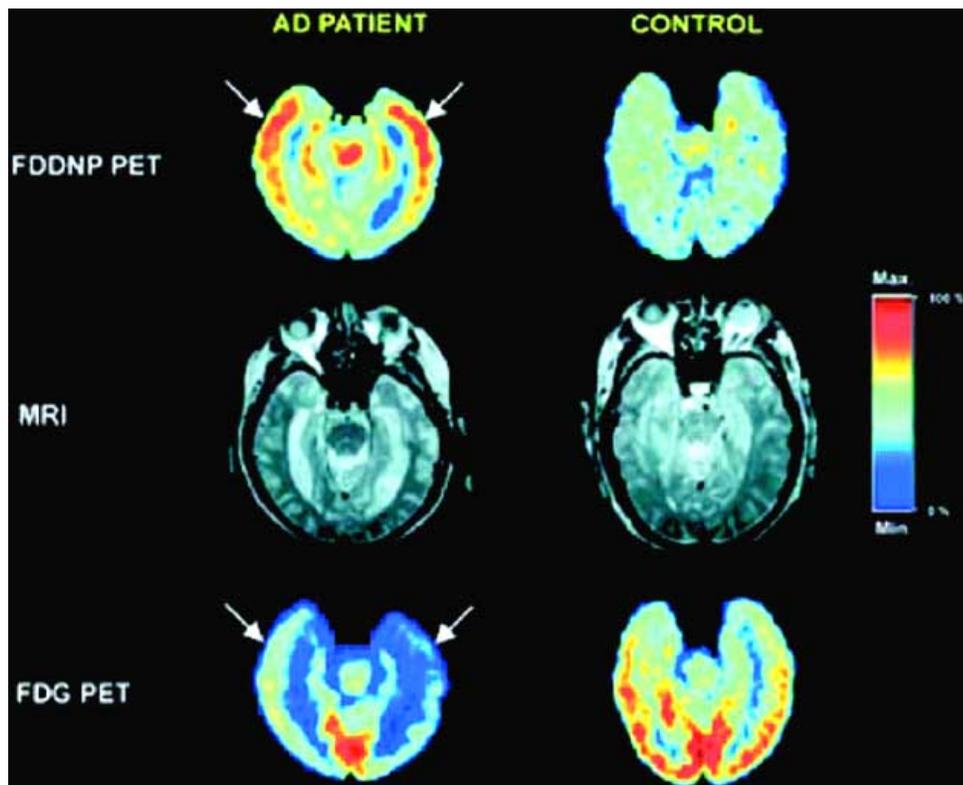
^{18}F -FDDNP-PET, MRI, and FDG-PET images of a patient with AD and a normal subject. The ^{18}F -FDDNP and FDG images of each stage are co-registered to their respective MR images. Areas of FDG hypometabolism are matched with the localization of neurofibrillary tangles and APs resulting from ^{18}F -FDDNP binding (arrows). The ^{18}F -FDDNP images represent activity 25-54 min after ^{18}F -FDDNP administration. The FDG images represent activity 20-60 min after FDG injection (reproduced with permission from [28]).
